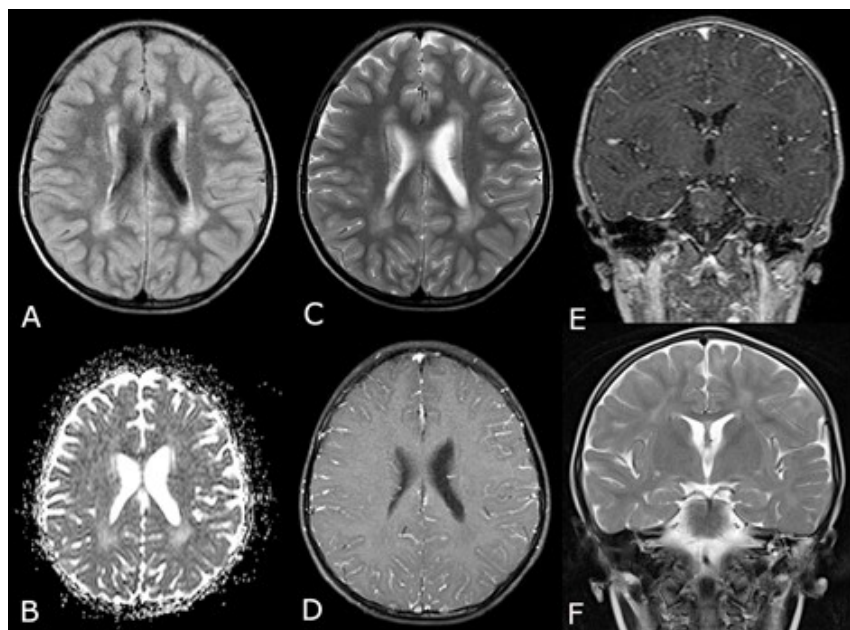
(A) Axial FLAIR-weighted image shows posterior periventricular white-matter hyperintensities. (B) Axial Apparent diffusion coefficient (ADC) map showing hyperintensities in the periventricular white-matter (reflecting absence of restricted diffusion). (C) Axial T2-weighted image shows posterior periventricular white-matter hyperintensities. (D) Axial and (E) Coronal T1-weighted image after gadolinium contrast, demonstrating absence of enhancement. (F) Coronal T2-weighted image without evidence of hippocampal abnormalities.
